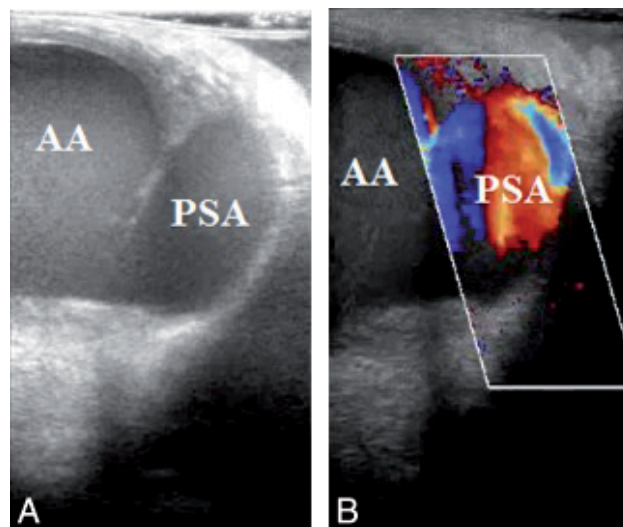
Epiaortic ultrasound demonstrating 1.6×1.0 -cm pseudoaneurysm along the medial side of the ascending aorta. Panel A. Ultrasound image alone. Panel B. Ultrasound with color Doppler. AA = ascending aorta; PSA = pseudoaneurysm.
